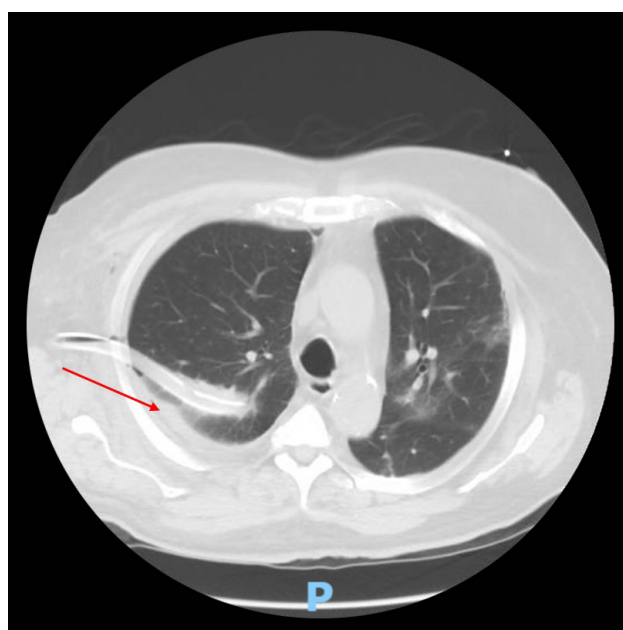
Non-contrast computed tomography of the chest showing right-sided chest tube placement. The arrow points to the residual effusion
